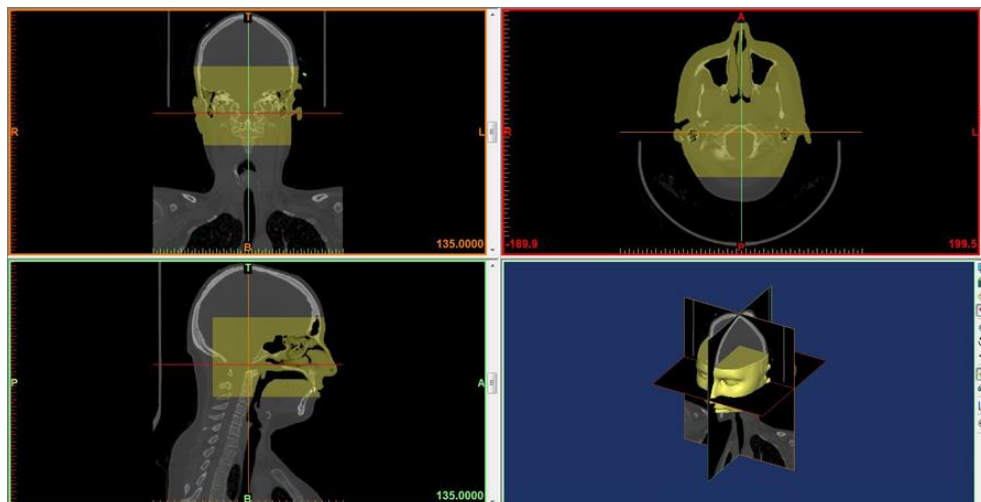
CT images of patient.
